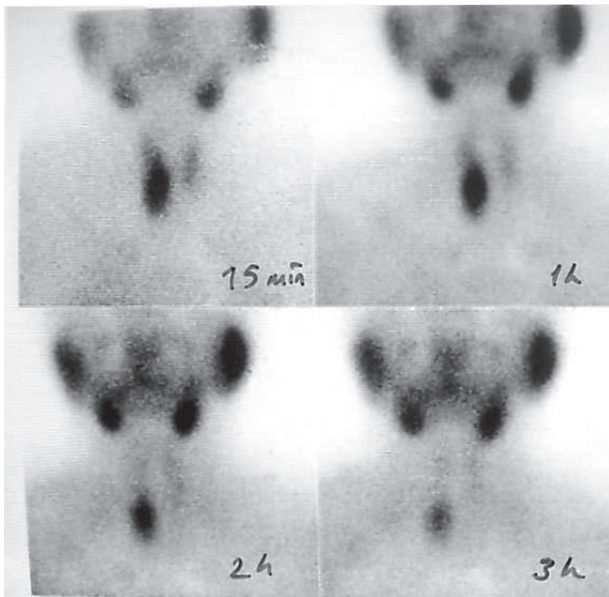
The early and triple late images of MIBI parathyroid scintigraphy in a patient with left lower oxyphil cell-predominant parathyroid adenoma (patient 16 in Table 1).
